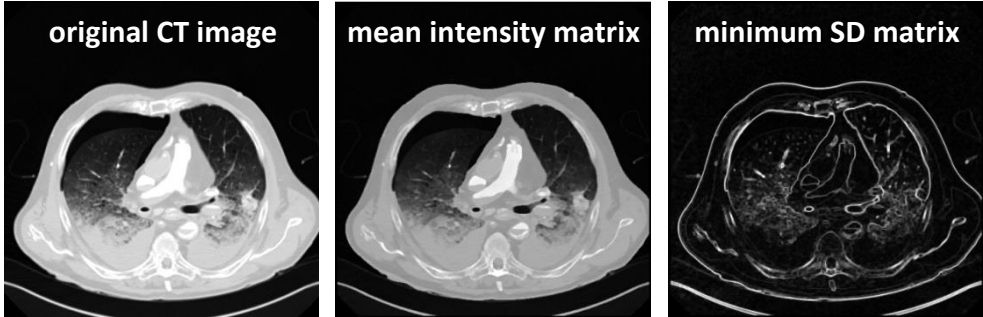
Example of an original CT image (left) together with its mean intensity matrix M (middle) and minimum SD matrix S (right).
